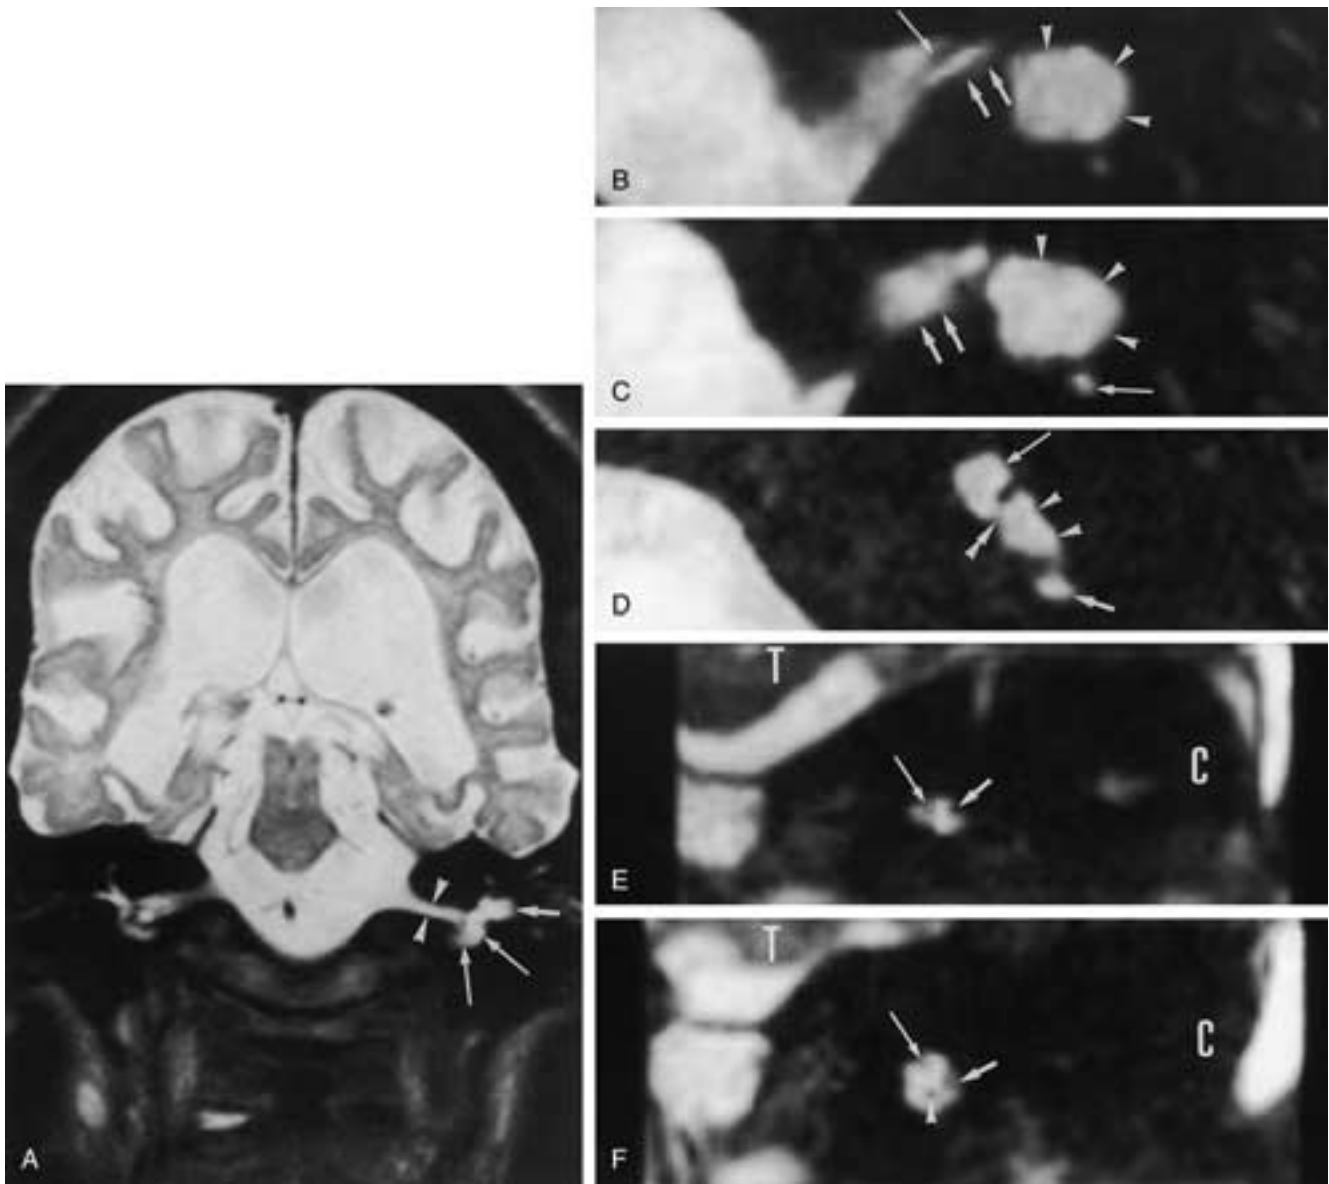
Cockayne's syndrome in a 20-year-old girl with atrophic appearance of the brain, severe dysplasia of the left inner ear, and malformation of the VCN. A, Coronal Turbo-SE T2-weighted image through the brain and inner ears. The ventricles and sulci are enlarged, and there is severe brain atrophy for a patient of this age, a typical finding in Cockayne syndrome. The left IAC is stenotic (*white arrowheads*), and the lateral semicircular canal (*small white arrow*) and cochlea (*long white arrows*) are enlarged in comparison with the normal right side. B to D, Axial 3DFT-CISS image through the upper part (B) and inferior part (C) of the IAC and through the inferior part of the abnormal membranous labyrinth (D). B, A fluid-filled "cystic vestibule/lateral semicircular duct" structure can be recognized (*white arrowheads*). The facial nerve (*long white arrow*) and a common VCN (*small white arrows*) can be seen near the fundus of the IAC. C, The cystic inner ear structure can again be depicted (*white arrowheads*), and the posterior semicircular duct has a normal appearance (*long white arrow*). The IAC contains CSF only at the level where normally a cochlear and inferior vestibular branch of the eighth nerve are found (*small white arrows*). D, A dysplastic cochlea (*long white arrow*) and vestibule (*white arrowheads*) can be found, and these structures are linked with one another (*double arrowhead*). Posterior semicircular duct (*small white arrow*). E and F, Parasagittal 3DFT-CISS reconstructions made perpendicular to the nerves in the middle one third of the left (E) and right (F) IAC. E, The facial nerve (*long white arrow*) and an undividing common VCN (*small white arrow*) can be seen in a narrowed IAC. F, Compare this with the normal size of the right IAC. A normal facial nerve (*long white arrow*), cochlear branch (*white arrowhead*), and common undivided vestibular branch (*small white arrow*) of the eighth nerve can be seen on the normal right side. Cerebellum (C), temporal lobe (T).
